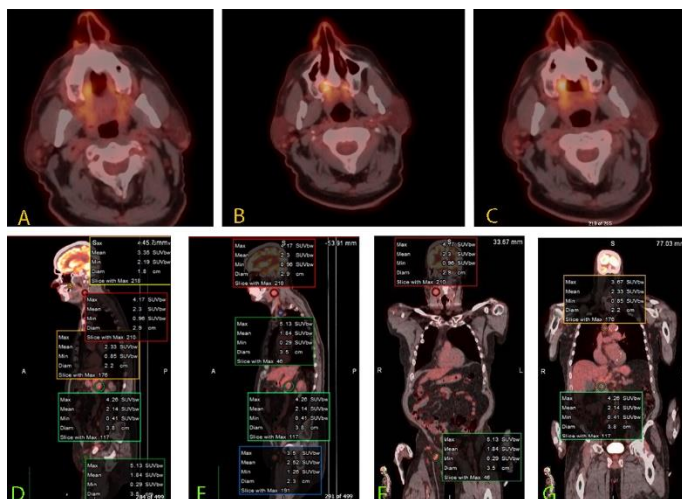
Positron-Emission Tomography/Computed Tomography (PET/CT) Findings.
